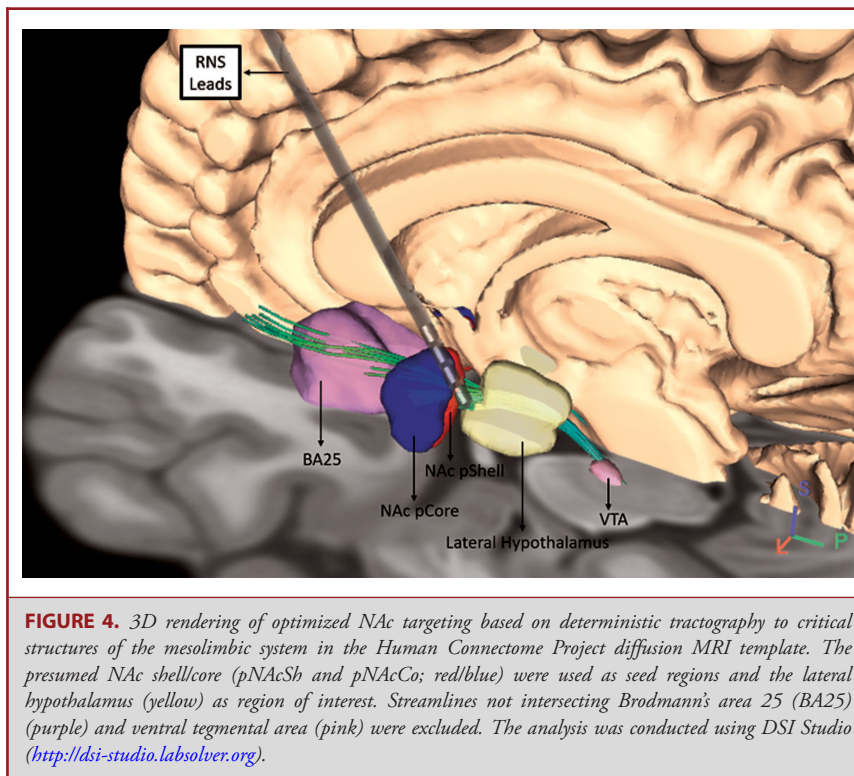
3D rendering of optimized NAc targeting based on deterministic tractography to critical structures of the mesolimbic system in the Human Connectome Project diffusion MRI template. The presumed NAc shell/core (pNAcSh and pNAcCo; red/blue) were used as seed regions and the lateral hypothalamus (yellow) as region of interest. Streamlines not intersecting Brodmann's area 25 (BA25) (purple) and ventral tegmental area (pink) were excluded. The analysis was conducted using DSI Studio (<http://dsi-studio.labsolver.org>).
